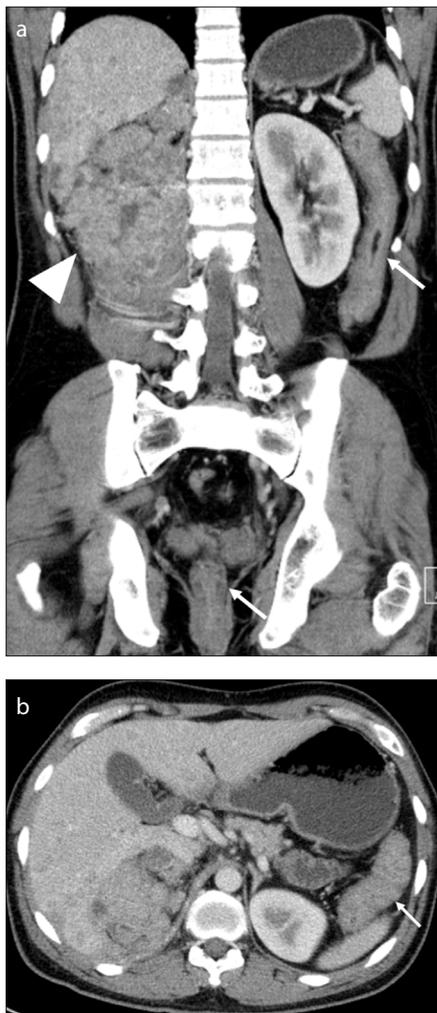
a, b. A 42-year-old man with a history of renal cell carcinoma (RCC) and right nephrectomy, undergoing HDIL-2 therapy presented with diarrhea. Coronal contrast-enhanced CT image (a) demonstrates a large recurrent mass within the surgical bed that invades the right iliopectus muscle (*arrowhead*) and liver metastases. Note the diffuse bowel wall thickening of the descending colon and rectum (*arrows*). Axial contrast-enhanced CT image (b) shows diffuse bowel wall thickening of the descending colon (*arrow*). The findings indicated HDIL-2-related colitis after the exclusion of infectious and inflammatory causes.
